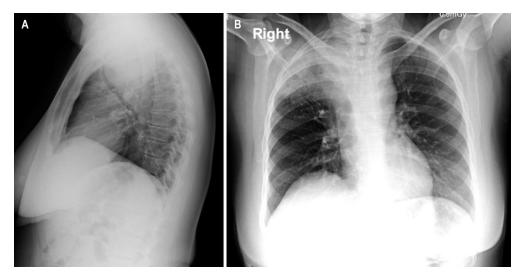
Chest X-ray. Mass located in the middle mediastinum with an internal air component in its upper region that does not rule out cavitation; this image communicates with adjacent consolidation of the right upper lobe, which does not rule out a fistulous tract. The mass produces an important compressive effect on adjacent structures, especially the trachea, with a decrease in its caliber of approximately 73%. Mass with involvement of the mediastinal pleura and the right apical pulmonary parenchyma, in direct contact with the right pulmonary artery, the aortic arch and the azygos vein arch without signs of infiltration. A. Lateral view. B. Posteroanterior view.
